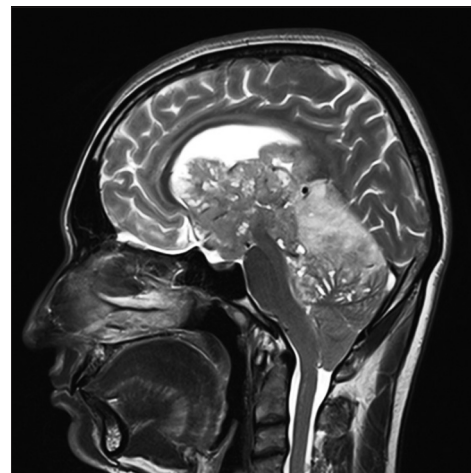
Magnetic resonance imaging of the brain showing a pineal mass
